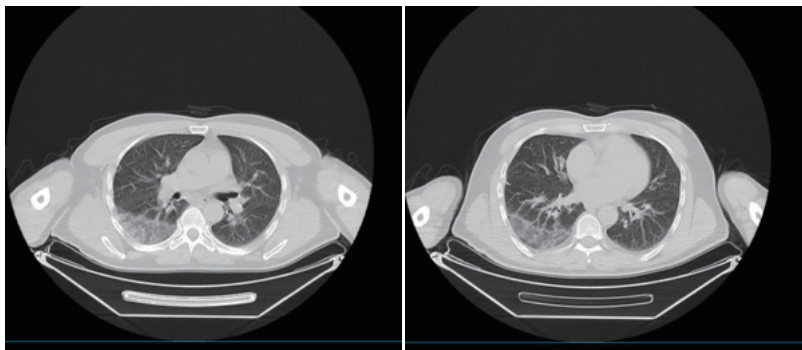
Significant bilateral frosted-glass image on the thorax CT in Case 4
